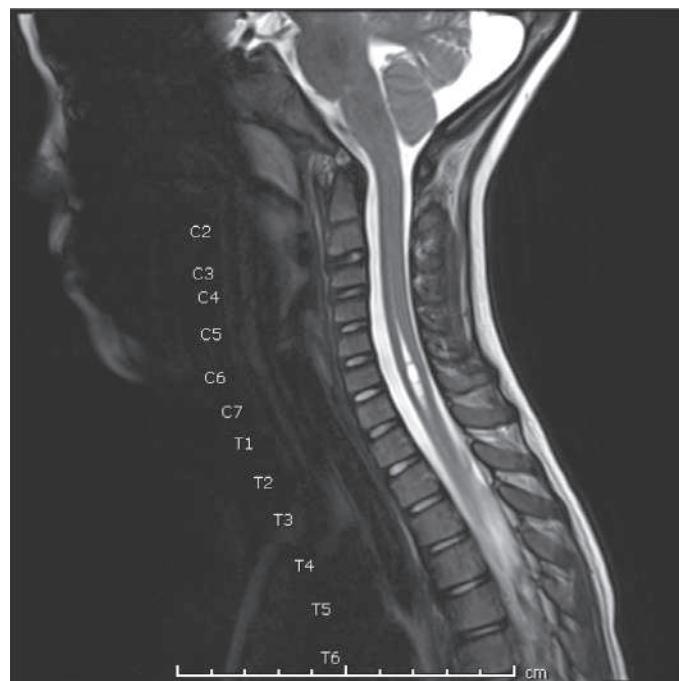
T2-weighted MRI scan of the cervical and thoracic spinal cord showing dilation of the central canal (C5-T1) in the absence of a Chiari malformation or other pathology.
